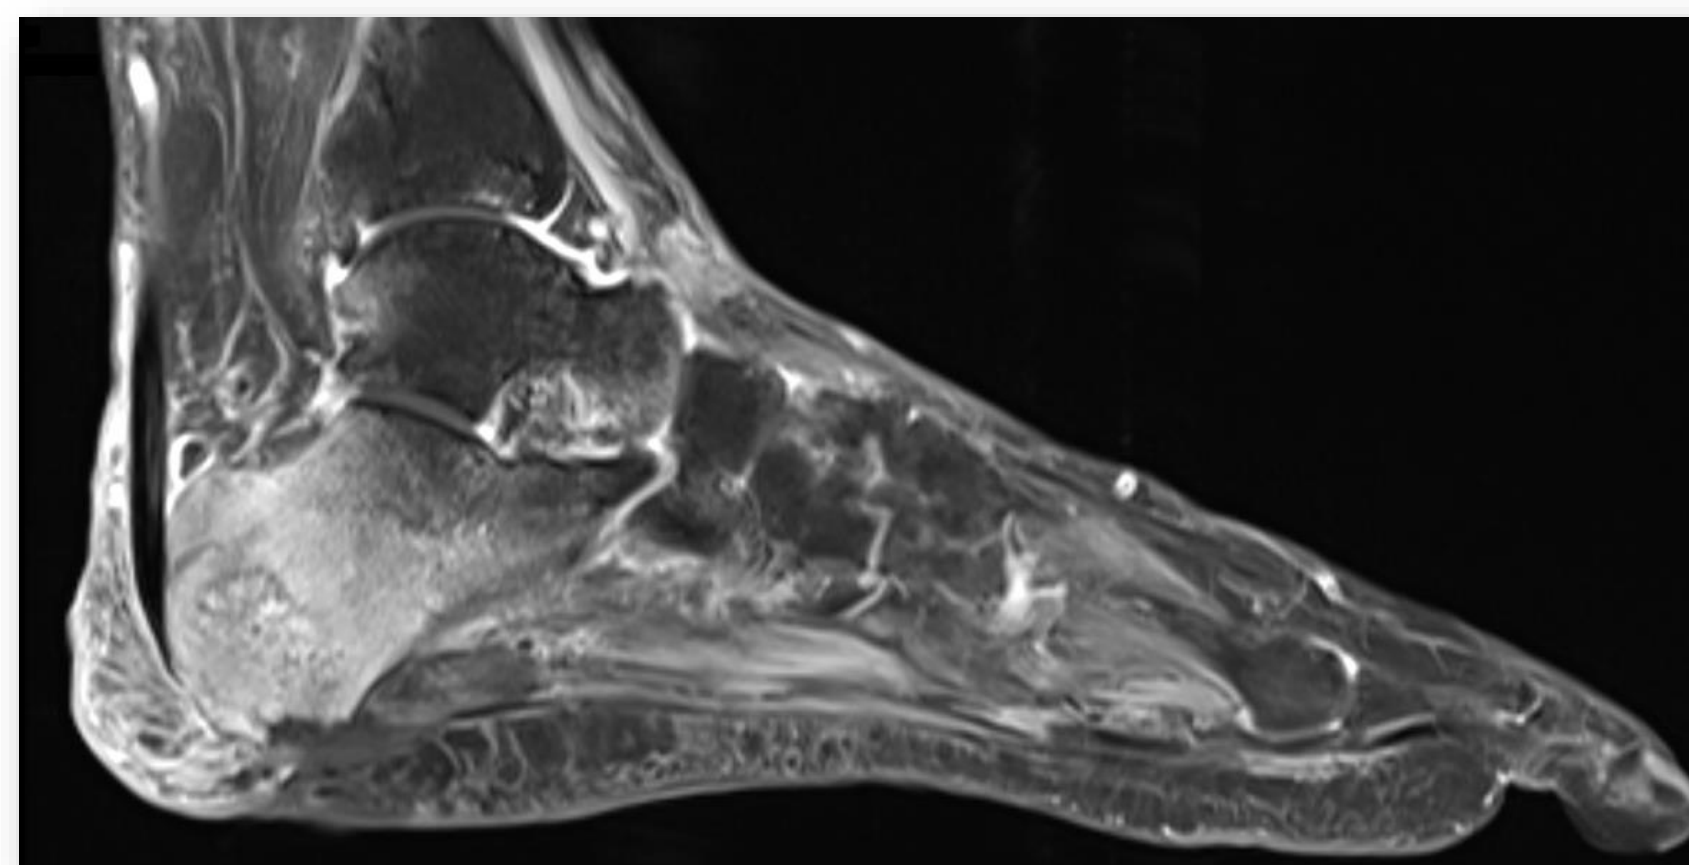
Lateral Left Foot MRI Initial Evaluation 6/10/16
